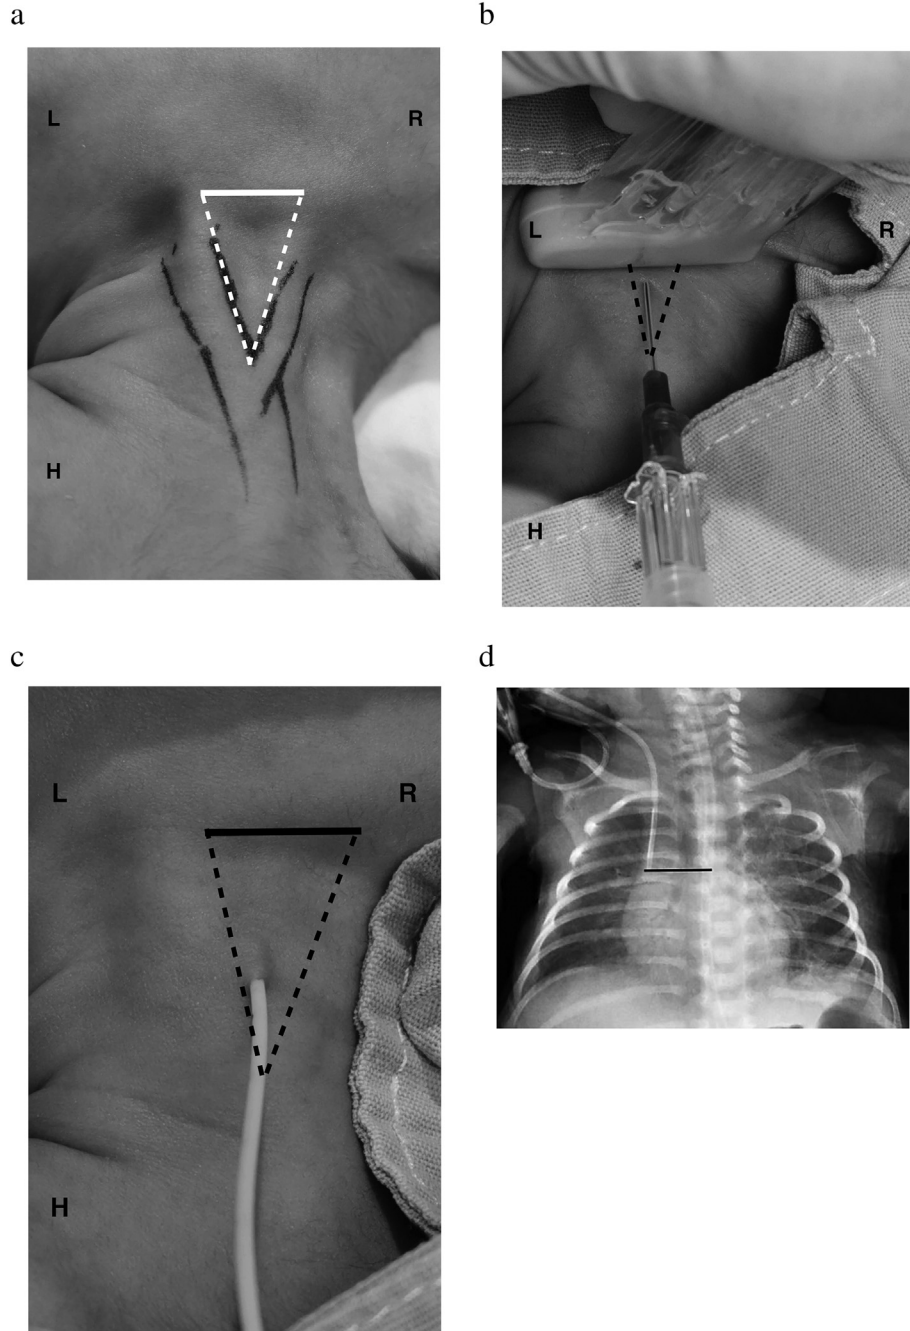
(a) Sedillot's triangle, the sternal head of the sternocleidomastoid muscle medially (dotted line to the patient left), the clavicular head of the sternocleidomastoid laterally (dotted line to the patient right), and the superior border of the medial third of the clavicle inferiorly (line). H: head, R: patient right and L: patient left. (b) The needle puncture was performed in real-time US guidance in short-axis at the apex of the Sedillot's triangle. H: head, R: patient right and L: patient left. (c) Catheter in the apex of the Sedillot's triangle. H: head, R: patient right and L: patient left. (d) Chest x-ray of catheter in adequate position is shown using the carina as an anatomical reference (horizontal line).
